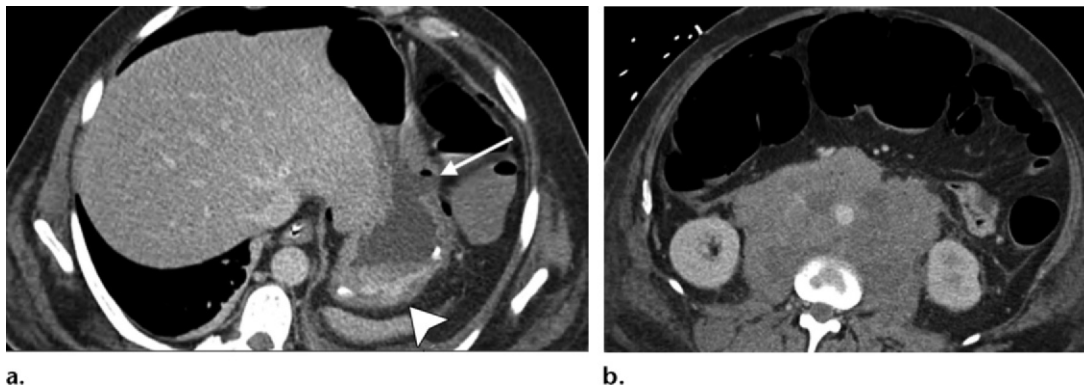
Gastric perforation from lymphoma. (a) Axial CT image shows transmurular ulceration of the gastric body with adjacent free intraperitoneal gas (arrow) and wall thickening in the gastric fundus (arrowhead). (b) Axial CT image shows a large retroperitoneal mass encasing the aorta and inferior vena cava.
